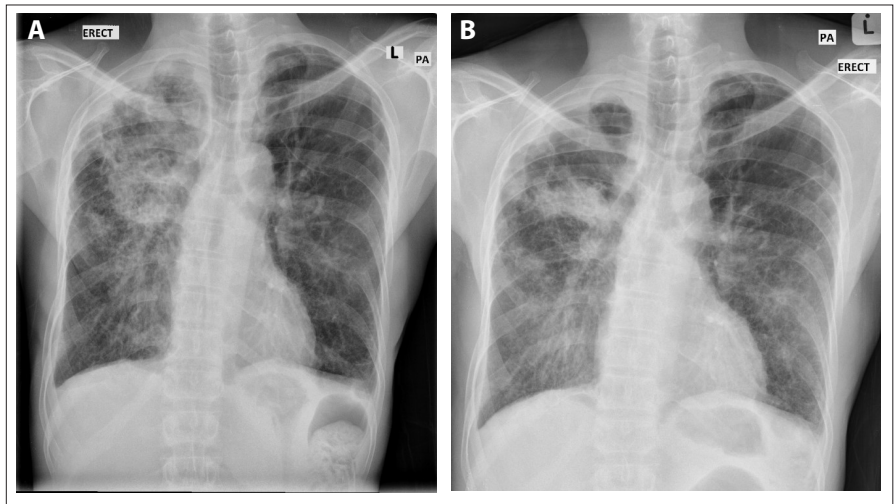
(A). Chest radiograph on admission to hospital and (B) Follow-up imaging after six weeks of voriconazole therapy.
